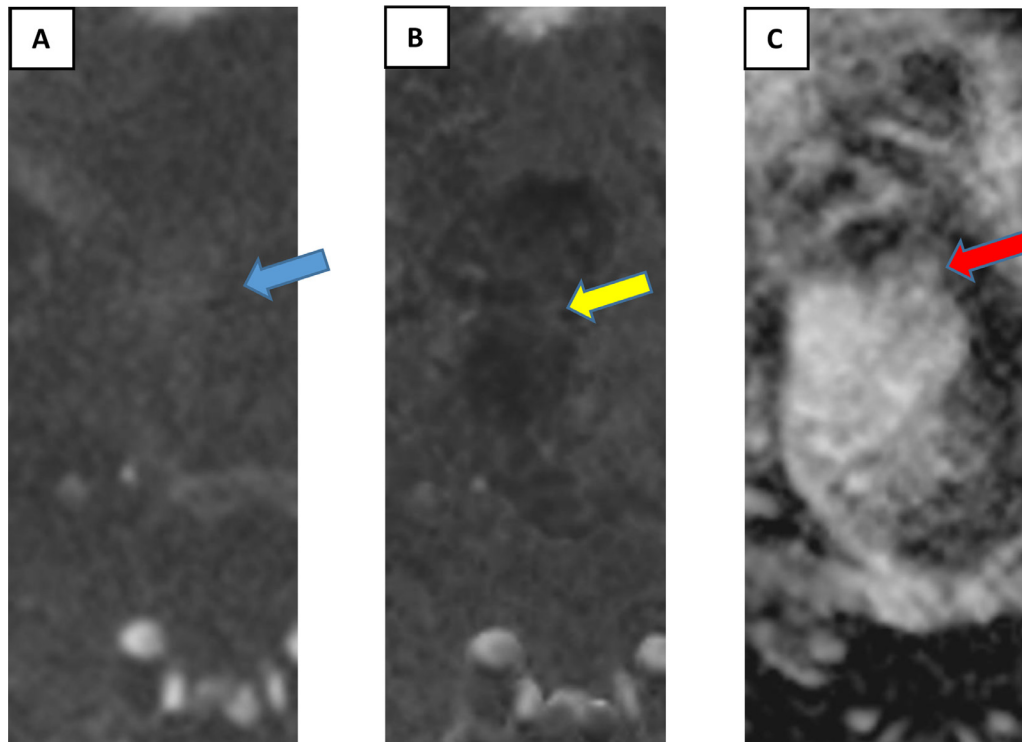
(A and C): Axial diffusion weighted imaging (DWI) with high b -value (1000 s/mm^2) (A, blue arrow) and calculated b -value (1600 s/mm^2) (B, yellow arrow) demonstrate a noted absence of high signal within the treatment site. On ADC map T2 dark through is seen (C, red arrow).
